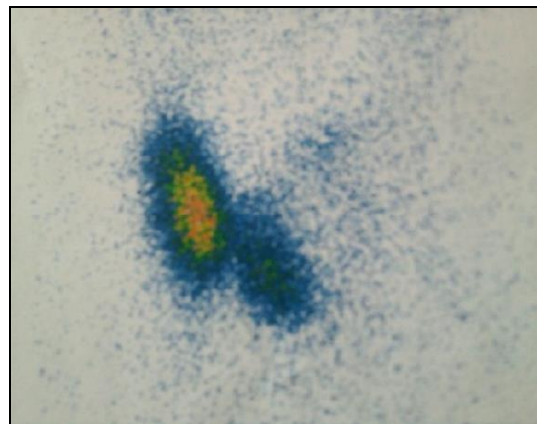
Technetium 99 scintigraphic image of the 2nd case showing a large cold lobar nodular formation.
